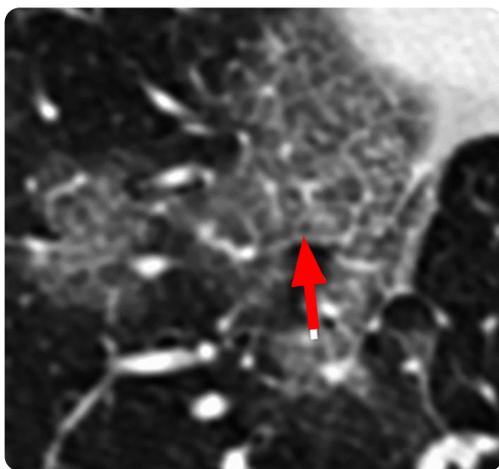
Paved pattern. Axial CT scan, without contrast medium. 65 year old patient with recent travel history to Wuhan, with fever and productive cough. A cobblestone pattern is observed, which is characterized by opacity in frosted glass associated with thickening of the interlobular septa towards the lower right lobe. Source: Taken with publication permission from Chung and collaborators (42).
